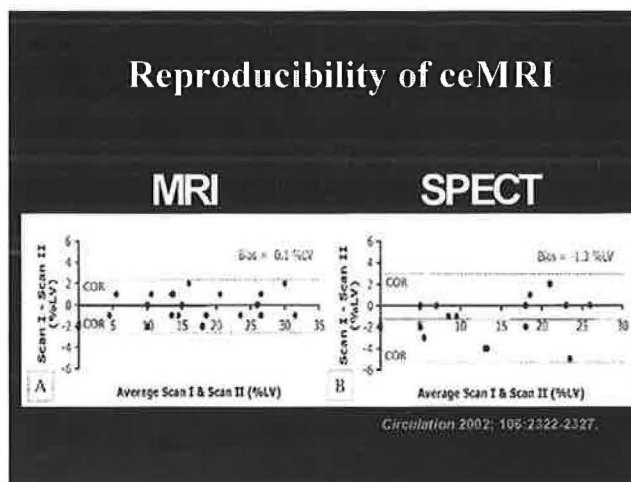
Both MRI and SPECT are reproducible in the assessment of infarct size. The reproducibility of MRI appears better than SPECT.
